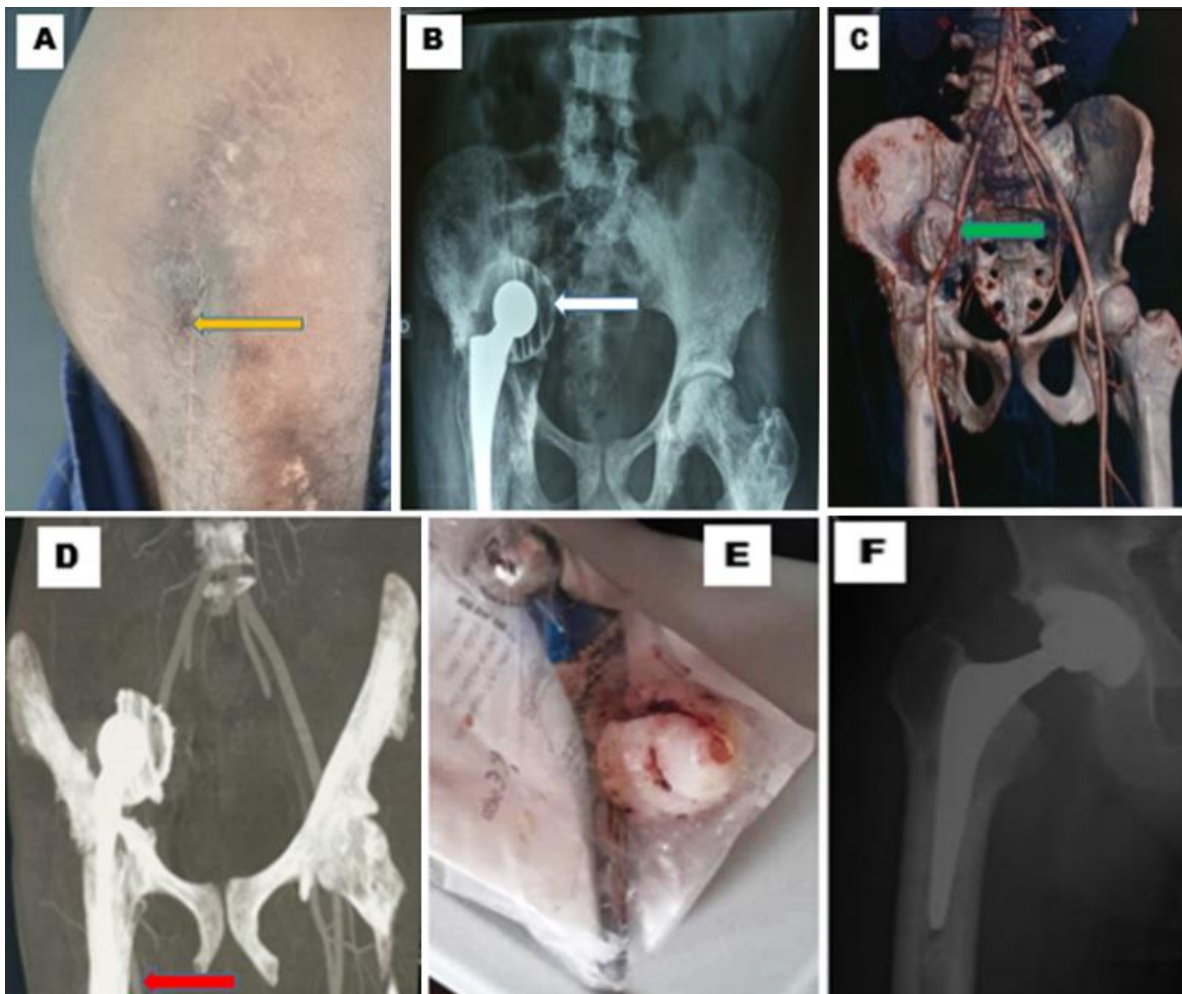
A) patient's right hip showing the previous operative scar with a fistula (yellow arrow); B) waist X-ray showing intra-pelvic dislocation of right hip prosthesis (white arrow); C) waist computed tomography showing intra-pelvic dislocation of the right hip prosthesis with medial deviation of right iliac arteries (green arrow); D) computed tomography angiogram showing permeable right iliac arteries (red arrow); E) image of the removed hip implant showing aspect of the hip implant after surgical removal; F) post-operative X-ray of right hip: final aspect after reimplantation of new cemented hip prosthesis
